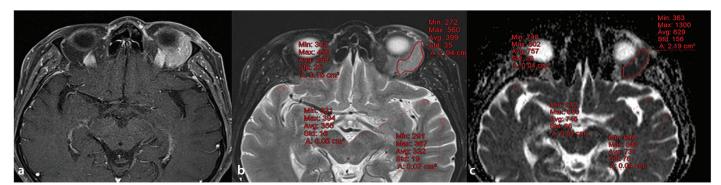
Representative example of lesion and reference cortical measurements in a patient with orbital lymphoma; using an axial fat-saturated post-contrast T1-weighted image (a) as a reference, manual regions of interest (ROIs) were placed to avoid cystic/necrotic components and lesion margins on the axial fat-saturated T2-weighted image (b) and apparent diffusion coefficient map (c); reference cortical ROIs were positioned in normal-appearing cortex while carefully avoiding white matter and sulci.
